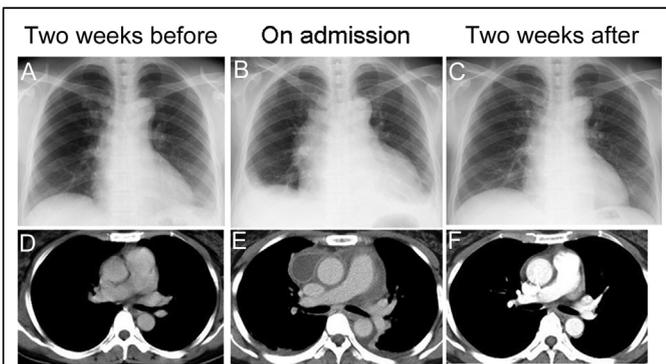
Chest X-ray (A, B, and C) and the chest contrast computed tomography (D, E, and F) in the present case. Two weeks before admission they showed no abnormal finding (A and D). On admission they showed pericardial effusion, a small amount of bilateral pleural effusion, and a mediastinal mass (B and E). They improved after 2 weeks (C and F).
